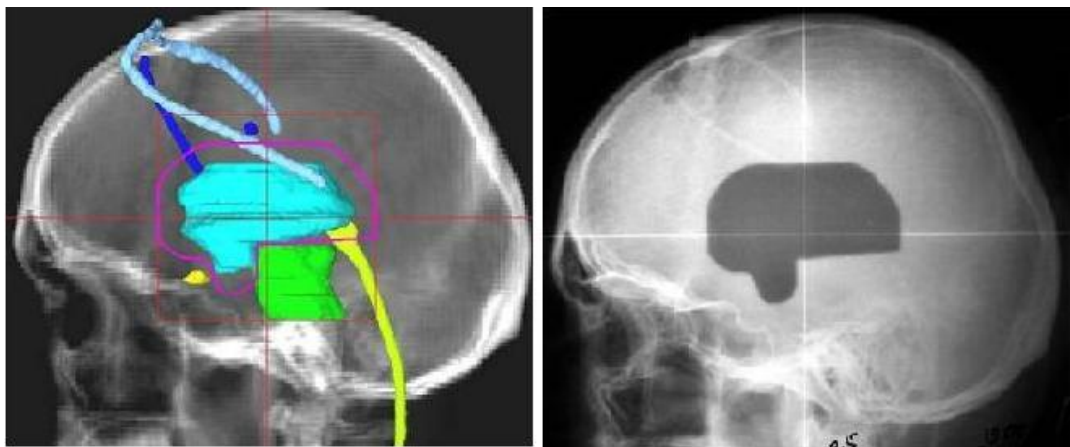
Verification of the proton irradiation plan: on the left - a digital X-ray of the skull from the irradiation direction with the projection of the target, critical structures and the collimator aperture; on the right – an X-ray of the skull before irradiation with mark of low-intensity proton beam exposed. The position of the beam relative to the bone structures-reference points and its shape exactly correspond to the plan of irradiation.
